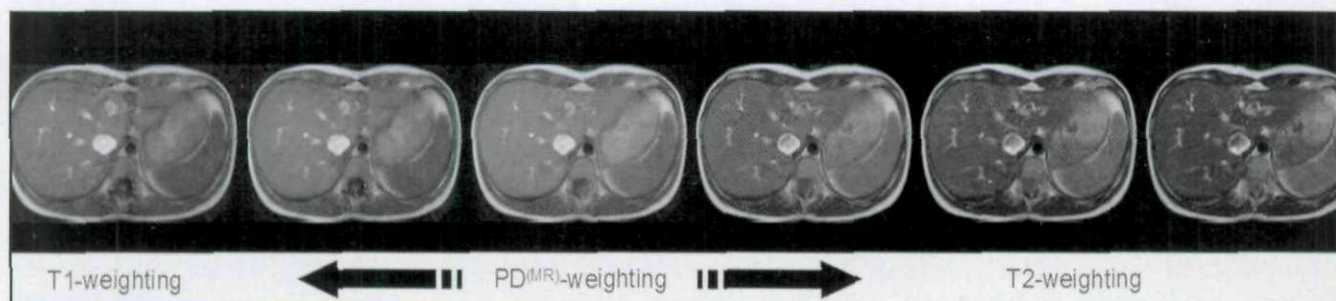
Magnetic resonance image synthesis in the abdomen. Images of user-variable weighting may be synthesized at the time of image interpretation. PD = proton density.
